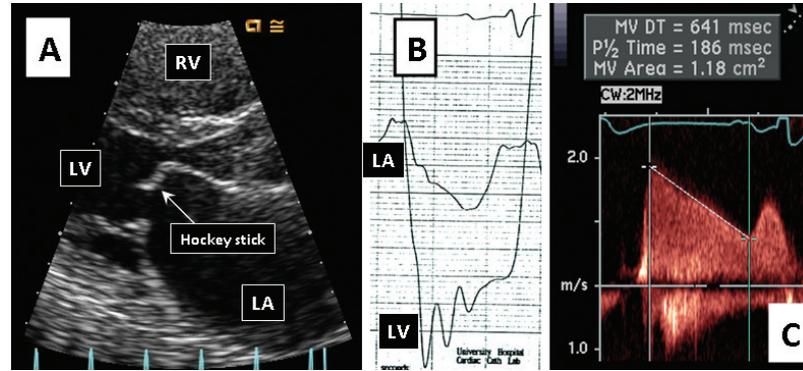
Mitral stenosis. Panel A shows a 2D transthoracic echocardiogram in the parasternal long-axis view of a patient with rheumatic mitral valve disease. The anterior mitral leaflet has the characteristic hockey stick appearance. Panel B represents simultaneous left atrial and left ventricular pressure recordings during cardiac catheterization. Note the marked separation between left ventricular diastolic pressure and the markedly elevated left atrial pressures indicative of severe mitral stenosis. Panel C demonstrates the echocardiographic pressure half-time method of determining the mitral valve area in a patient with moderate mitral stenosis. LA, left atrium; LV, left ventricle; RV, right ventricle.
